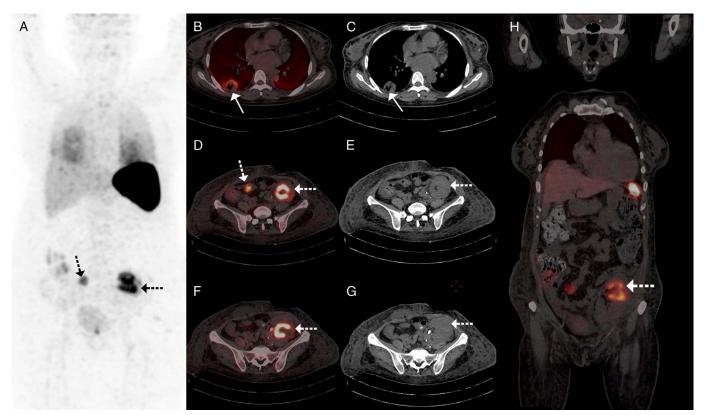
A 40-year-old woman presented to the hospital with chief complaint of persistent fever since 15 days. Patient was an old-treated case of severe form of COVID-19 requiring intensive care unit admission and had received high dose of steroid for a duration of 10 days. The patient also had prior history of renal transplant recipient 8 months back. Her blood culture was negative for growth of microorganism during hospital stay. ¹⁸F-FDG-labeled leukocytes PET/CT scan (MIP image, A) was performed for detection of occult site of infection, which revealed focal accumulation of radiotracer in a thick-walled fibrocavitatory lesion in the posterior basal segment of the right lung lower lobe with perilesional ground glass haziness (B and C, arrow) in terminal ileum and caecum (D–H, dotted arrowhead), suggestive of disseminated infection.
